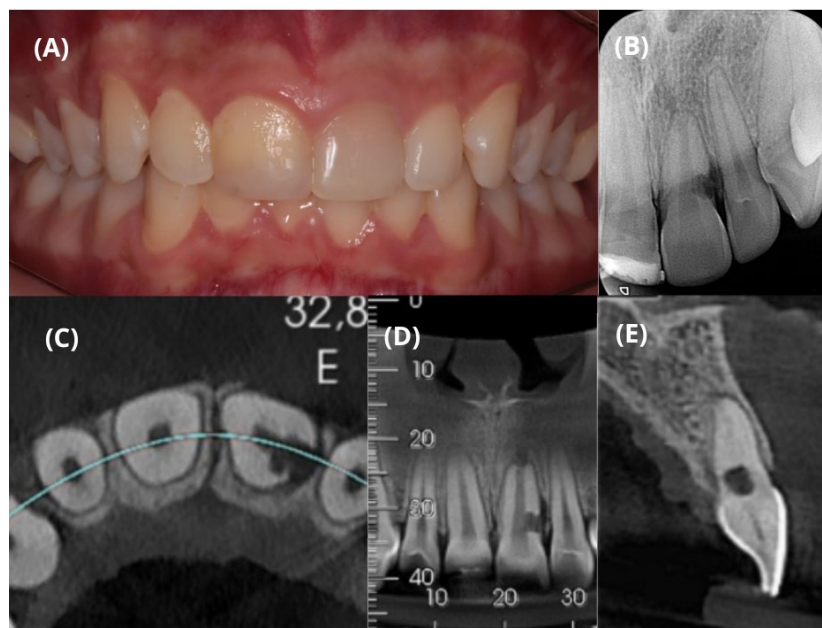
A) Initial clinical appearance of tooth #21; B) Initial radiographic appearance of tooth #21 with invasive cervical resorption; C, D, and E) Initial axial, coronal and sagittal tomography sections, respectively
